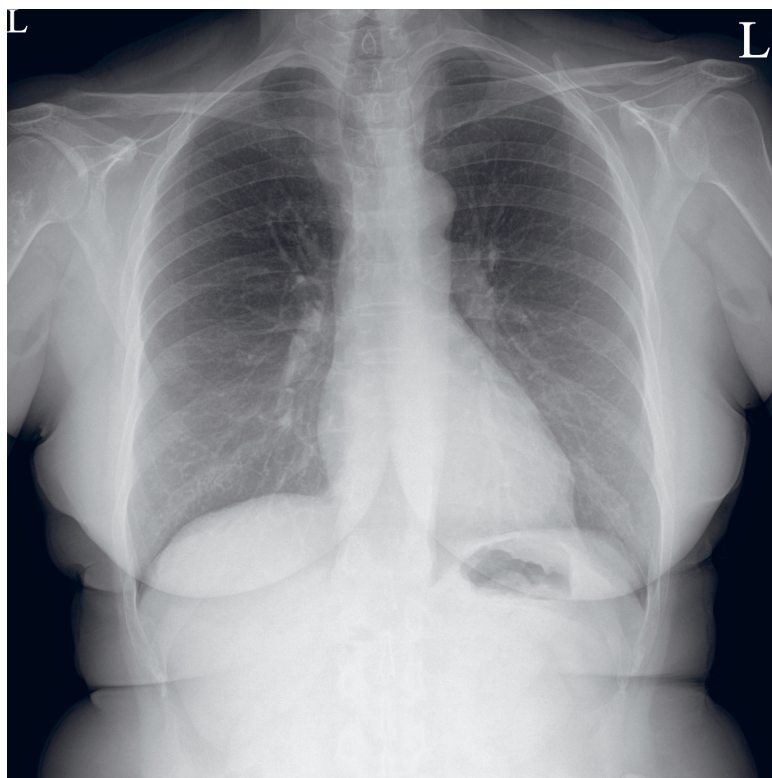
Chest radiograph. The air column in the trachea is of adequate width, slightly arched and pushed to the right at the level of the cervicothoracic junction.
